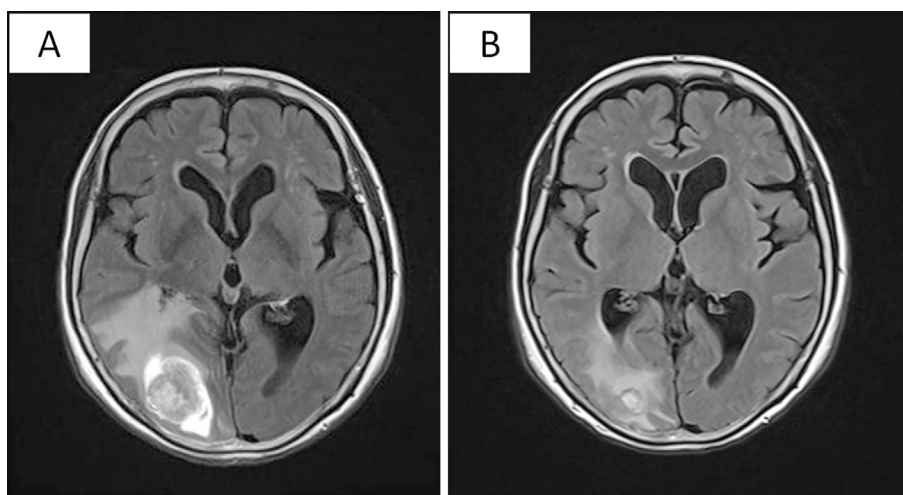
(a) Brain metastasis before osimertinib administration. Head magnetic resonance imaging showing metastasis in the right occipital lobe. (b) Magnetic resonance imaging one month after treatment with osimertinib showing a reduction in brain metastasis.
